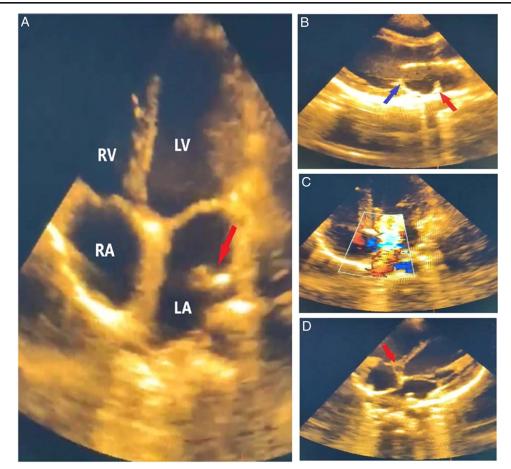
(A) Transthoracic echocardiography, LA left atrium; LV left ventricle; RA right atrium; RV right ventricle; red arrow indicates the intra-atrial malformation. (B) Additional view of the atrial malformation, indicated by red arrow; blue arrow indicates mitral valve. (C) Blood flow in the left atria, intra-atrial transeptal PG = 2 mmHg. (D) Ventricular septal defect (VSD) with septal aneurysm, indicated by red arrow. LA, left atrium; RA, Right atrium.
